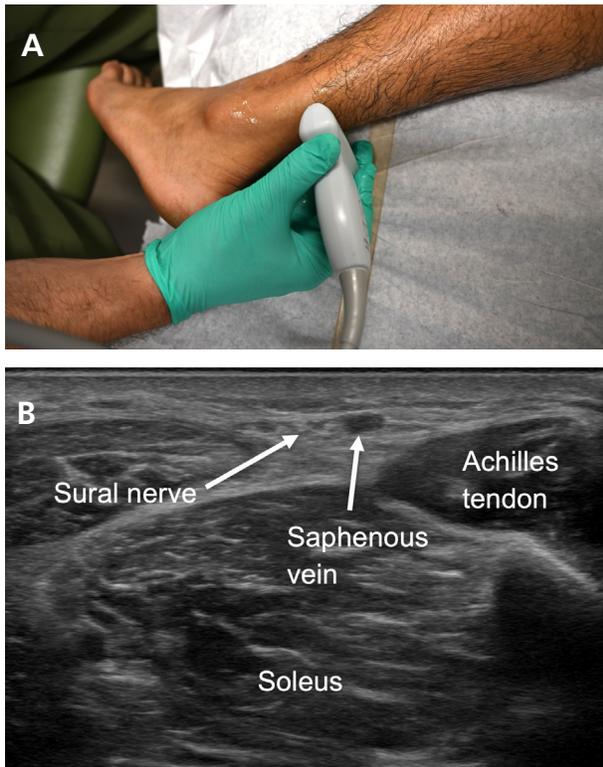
A) Patient and ultrasound positioning to visualize the sural nerve. B) Ultrasound visualization of the sural nerve via the saphenous vein.
